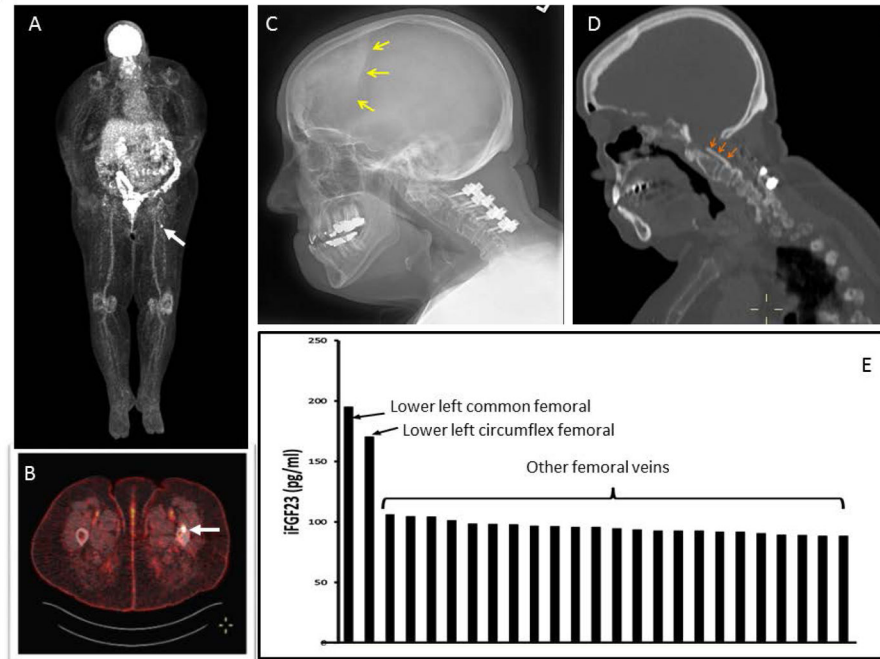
Localization studies subject 2: Panels A, B: FDG PET demonstrating positive uptake in left proximal femur (white arrows). Panel C: Skull image demonstrating calcified duramater (yellow arrows). D. Orange arrows demonstrating calcified posterior longitudinal ligament in cervical spine area indicating the long-standing hypophosphatemia. E. Selective venous sampling for iFGF23. There was a significant step-up in iFGF23 concentration as the suspected tumor venous drainage was approached anatomically (lower left common and circumflex femoral veins).
